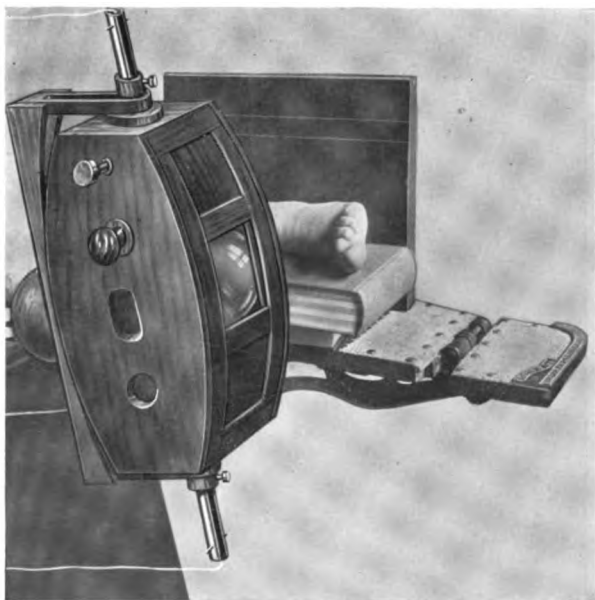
Radiography in Pott's fracture. The author's lateral plate-holder. Tube enclosed in a Ripperger shield.
